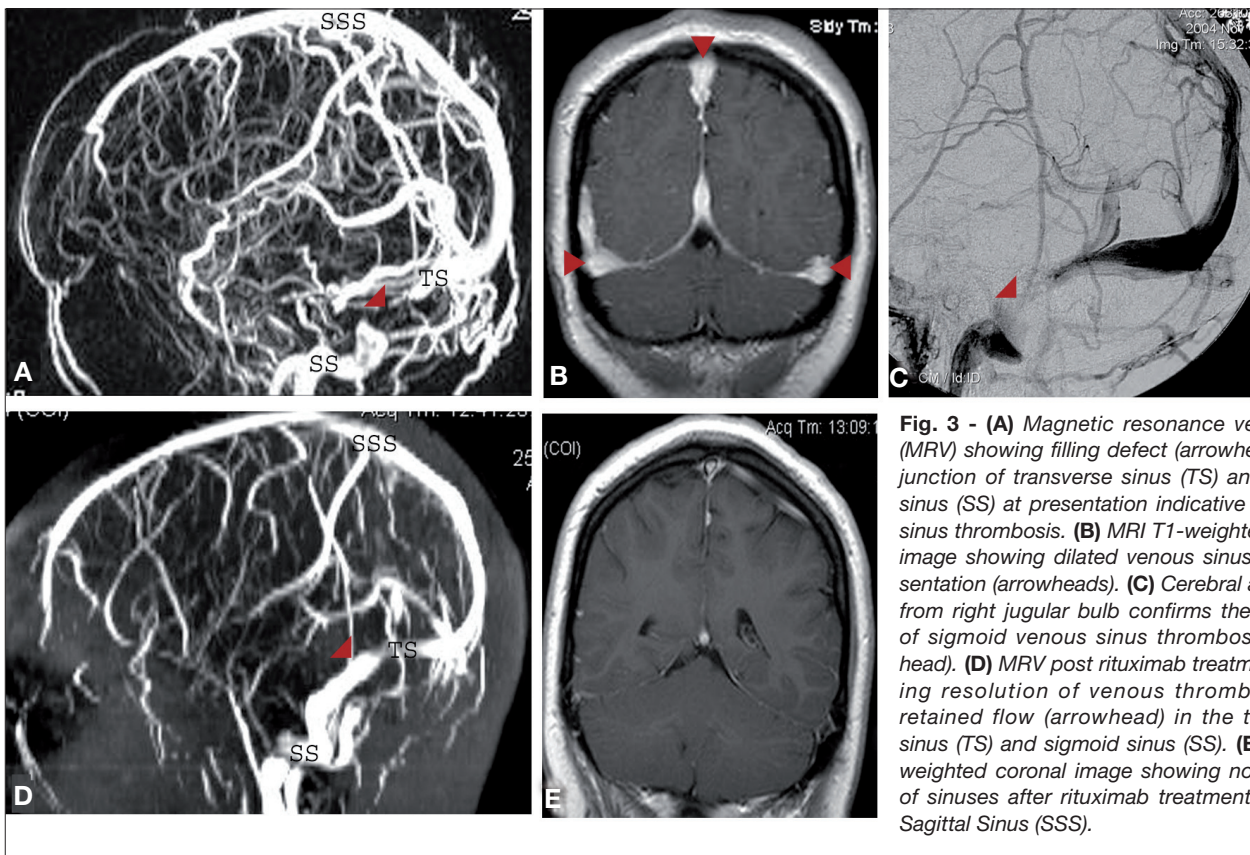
(A) Magnetic resonance venography (MRV) showing filling defect (arrowhead) at the junction of transverse sinus (TS) and sigmoid sinus (SS) at presentation indicative of venous sinus thrombosis. (B) MRI T1-weighted coronal image showing dilated venous sinuses at presentation (arrowheads). (C) Cerebral angiogram from right jugular bulb confirms the presence of sigmoid venous sinus thrombosis (arrowhead). (D) MRV post rituximab treatment showing resolution of venous thrombosis with retained flow (arrowhead) in the transverse sinus (TS) and sigmoid sinus (SS). (E) MRI T1-weighted coronal image showing no dilatation of sinuses after rituximab treatment. Superior Sagittal Sinus (SSS).
